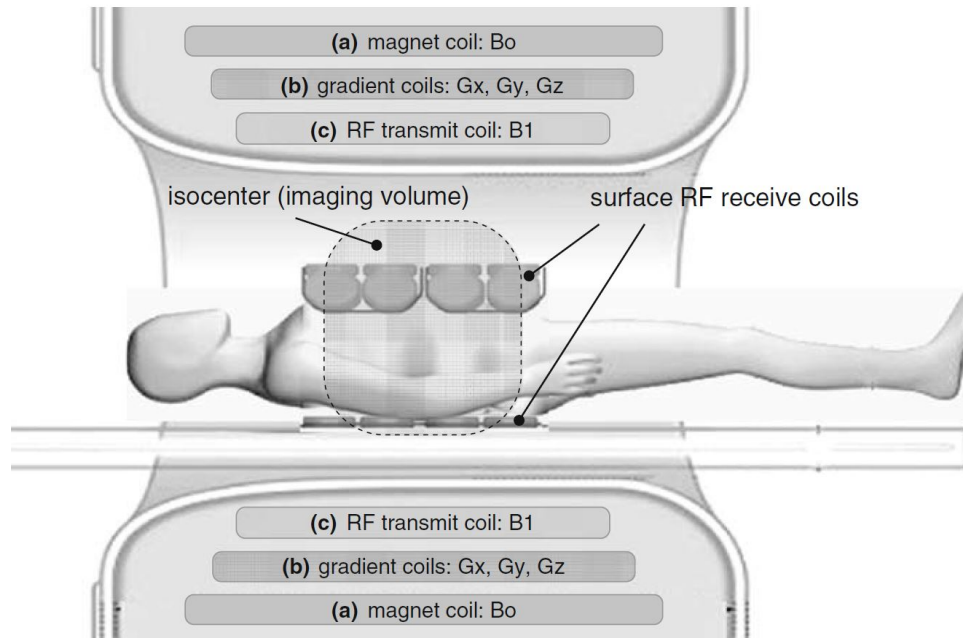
Scheme of a MRI system. (a) magnet coil to produce the homogeneous static magnetic field (B_0) for spin alignment; (b) gradient coils to produce the time-varying gradient fields (G_x , G_y and G_z) for spatial encoding of the MR signals, and (c) transmitter radiofrequency (RF) coil to generate an RF field (B_1) for spin excitation. The MR signal response from the excited spins within the subject is detected by a set of receive-only surface RF coils placed above and below the image volume [Moser *et al.* (2009)].
